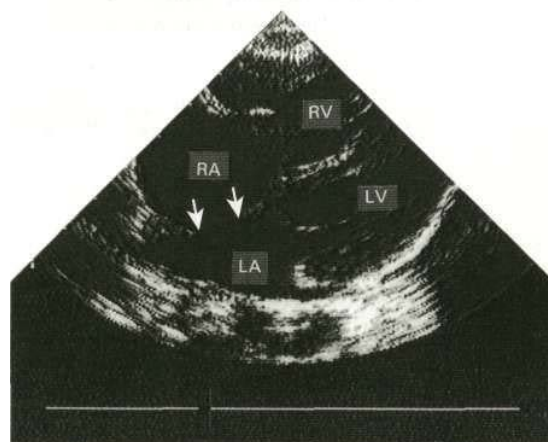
1fl Ostium secundum atrial septal defect (arrowed) in a young girl, shown by a two-dimensional echocardiogram subcostal four-chamber view (similar to Fig. 13.89, but rotated clockwise). Colour Doppler can demonstrate the left-to-right shunt. LA, left atrium; RA, right atrium; LV, left ventricle; RV, right ventricle.
